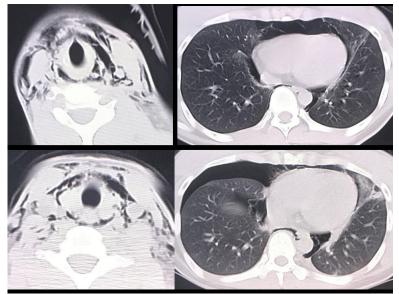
Computed image (CT) of trunk on arrival (upper images) and 16 h later (lower images). There was no pneumothorax on arrival; however, follow-up CT revealed right pneumothorax despite a reduction in the subcutaneous emphysema at the neck and the volume of pneumomediastinum
